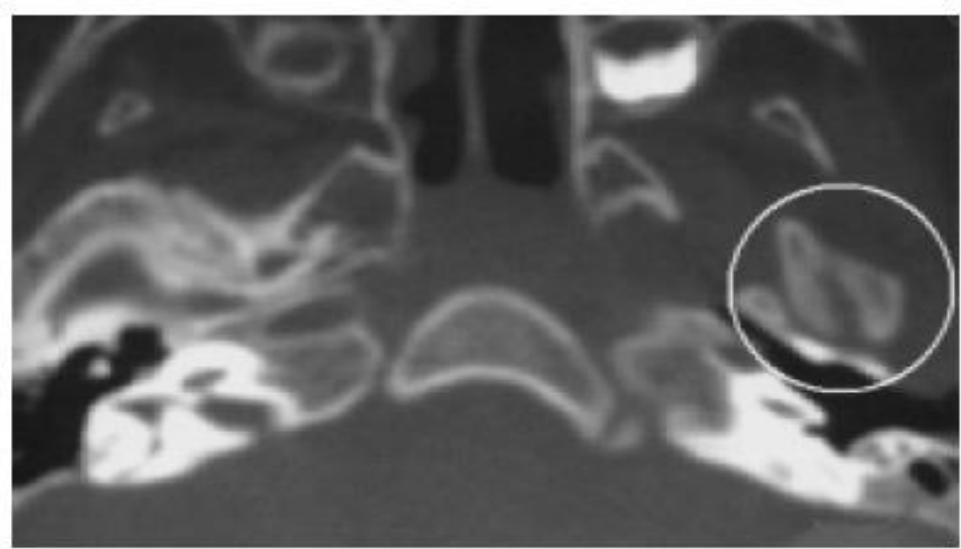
2D-CT axial view (bone window) demonstrates the bifid mandibular condyle in the left side with mediolateral heads. (white circle).
